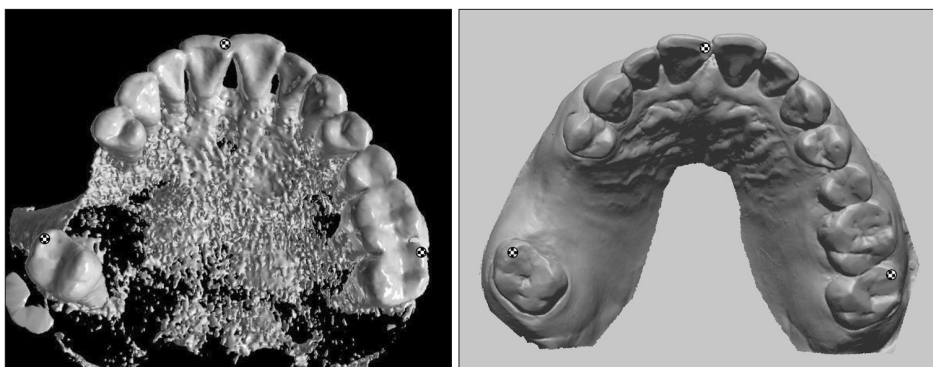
Image registration process between radiographic and optical scan data using point-based automatic image matching.
